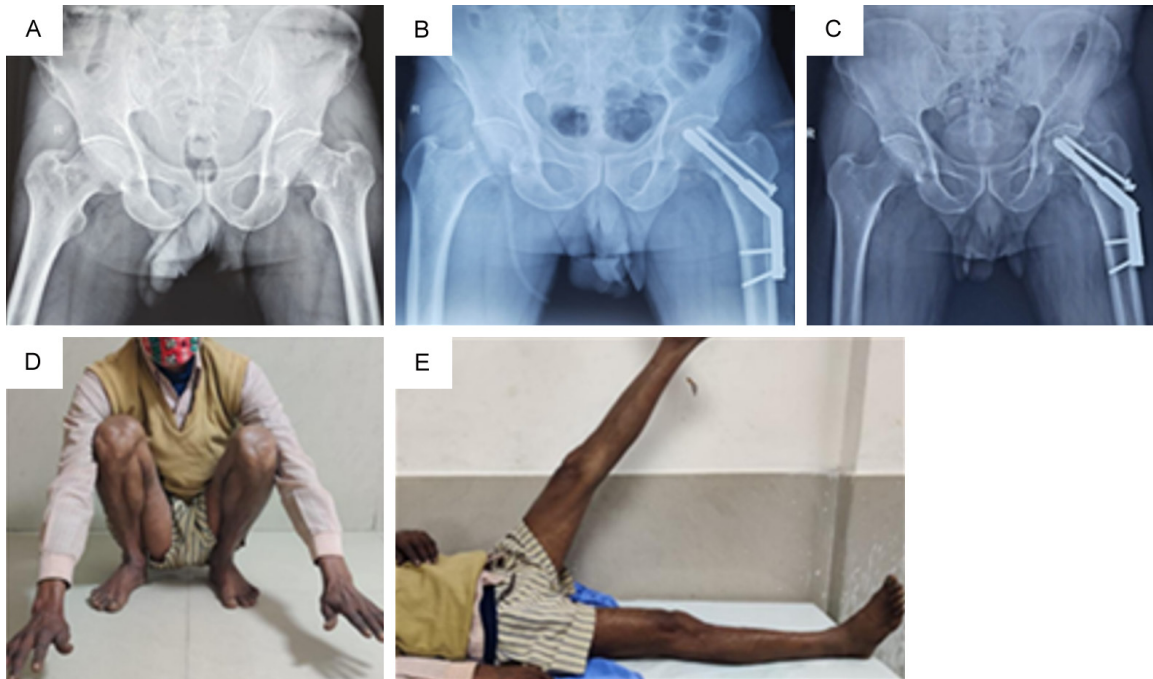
45 year/male patient presented with injury to left hip. X-ray showed fracture neck of left femur (A), CRIF with DHS and AS was done. Immediate postoperative x ray showed well placed implant (B), X-ray at 1 year follow-up showed union with some neck shortening (C), Functional outcome at 1 year (D, E).
